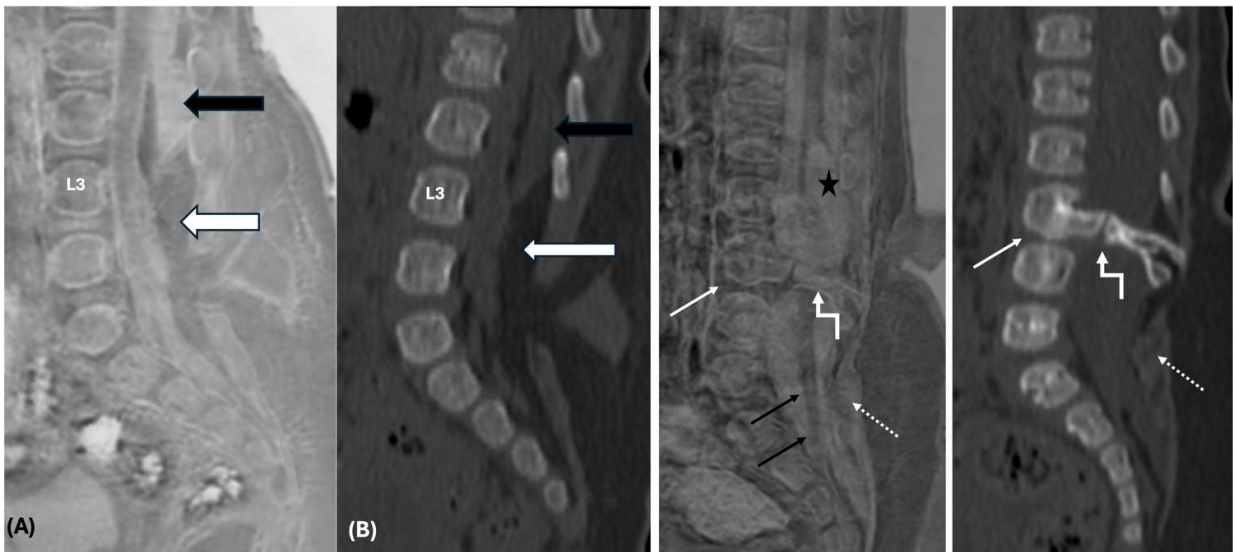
(A) Sagittal CS-FRACTURE MR and (B) CT bone window images in a 6-month-old show defect in the posterior elements from L3 level down with a closed spina bifida deformity. In addition, there is an arachnoid cyst (black arrows) which shows CSF like signal on FRACTURE MRI. The cord is seen low lying and lipoma-neural placode interface lies within the spinal canal suggesting a lipomyelocoele (white arrows). (C) Sagittal CS-FRACTURE and (D) CT bone window images in a 6-month-old show partial fusion of L3 and L4 vertebral bodies (white solid arrow), posterior element defects from L4 below (dotted arrow). An osseous bar (elbow arrow) is seen at L3-4 level resulting in hemi cords suggestive of Pang type 1 diastematomyelia. Syrinx (star) and low-lying cord (black arrow) are well seen on FRACTURE images. Also note the low bone signal and lack of cortical maturation in both the patients due to their very young age and cartilaginous vertebrae.
